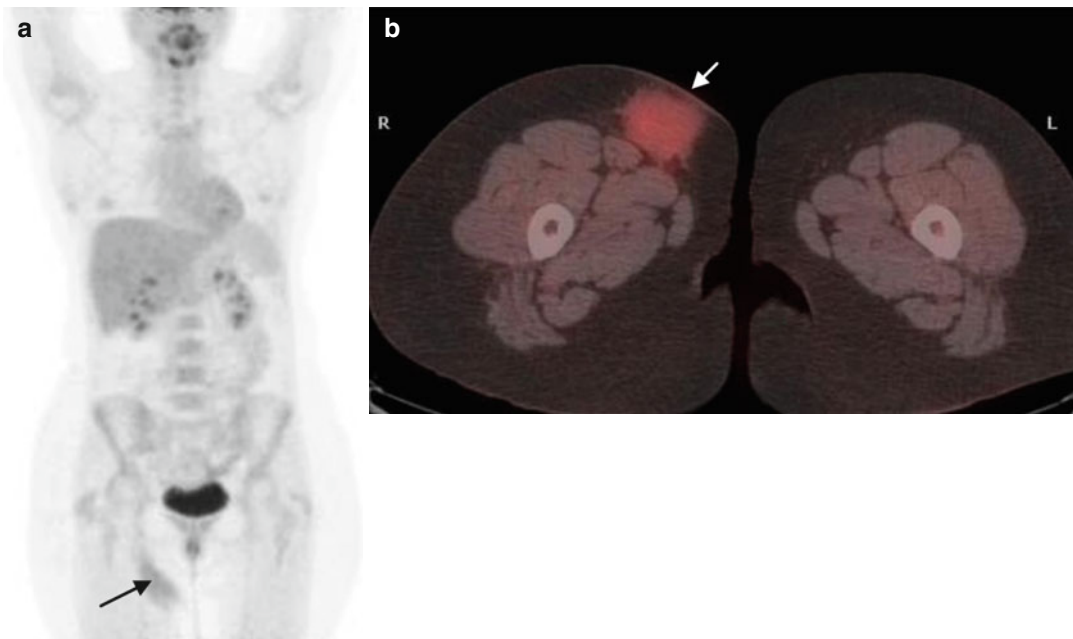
(a, b) MIP-PET and fused PET/CT post-chemotherapy: Mildly increased 18FDG uptake (SUVmax of 2, higher than that of the mediastinum but lower than
